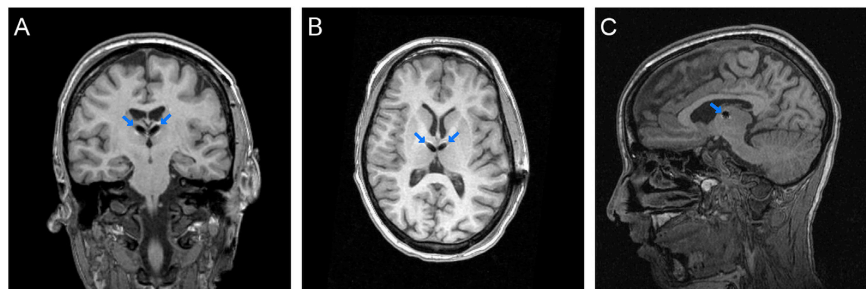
Postoperative MRI images from a representative patient. Representative coronal (A), axial (B), and sagittal (C) MRI images from a single patient demonstrating lead placement (highlighted by arrows).
